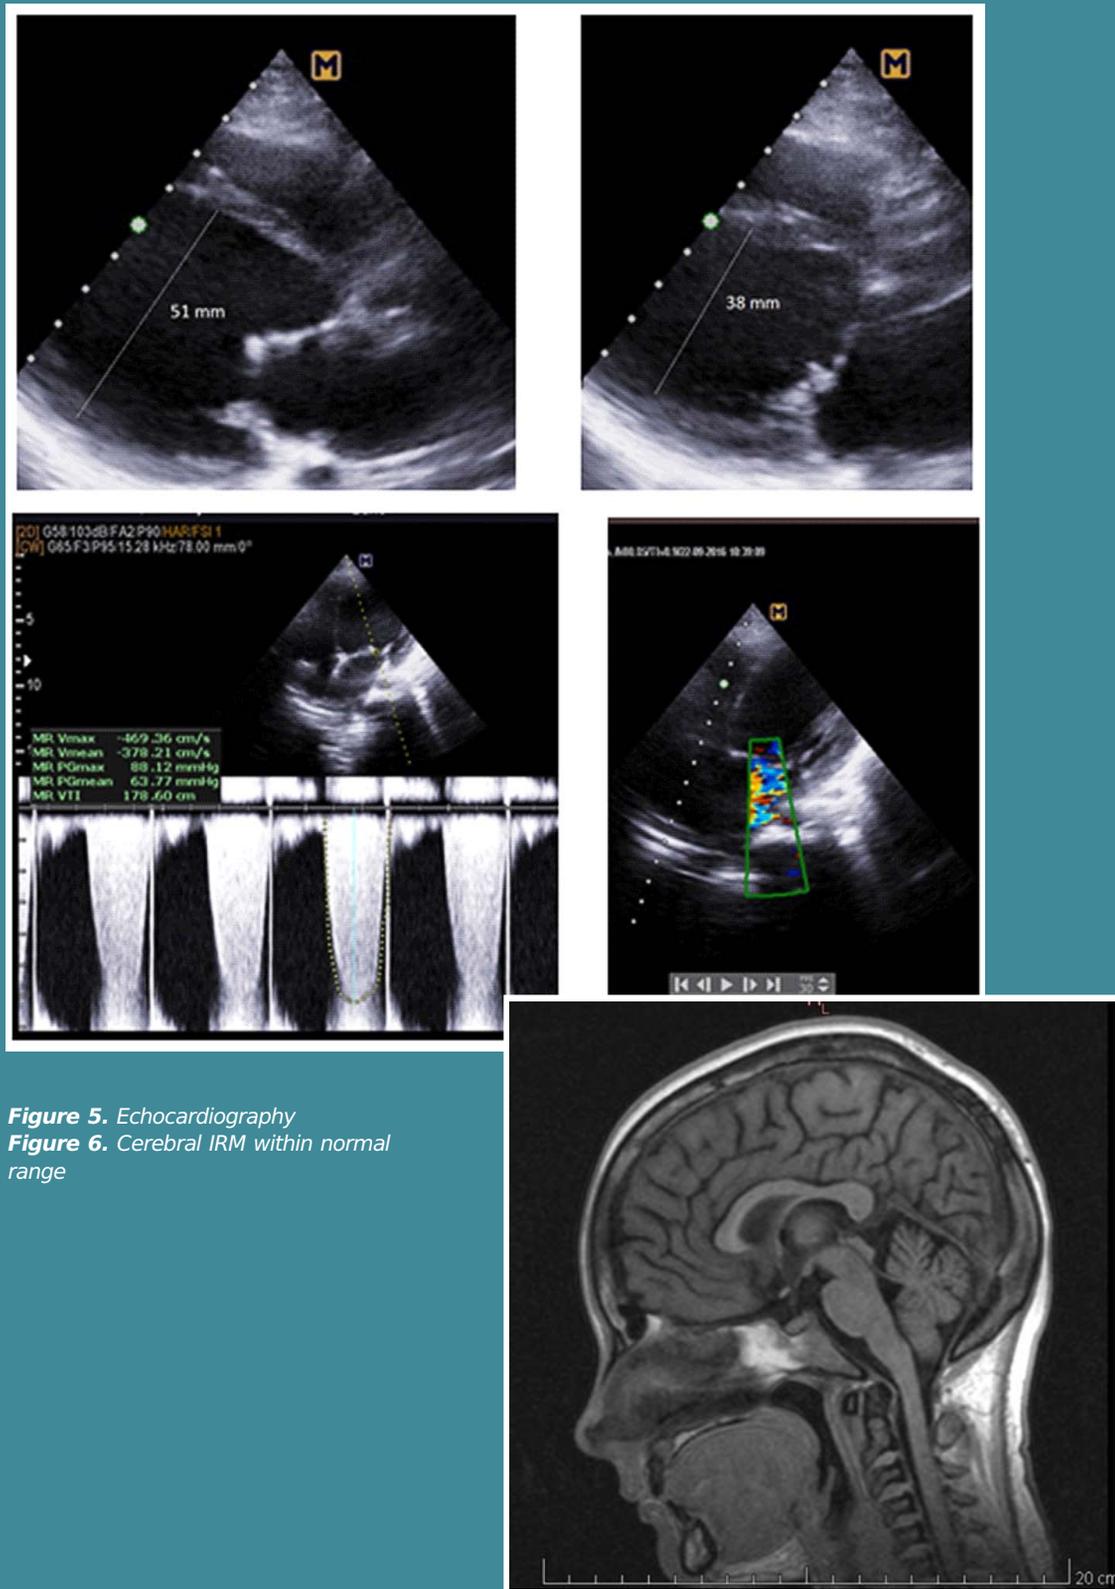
Echocardiography
